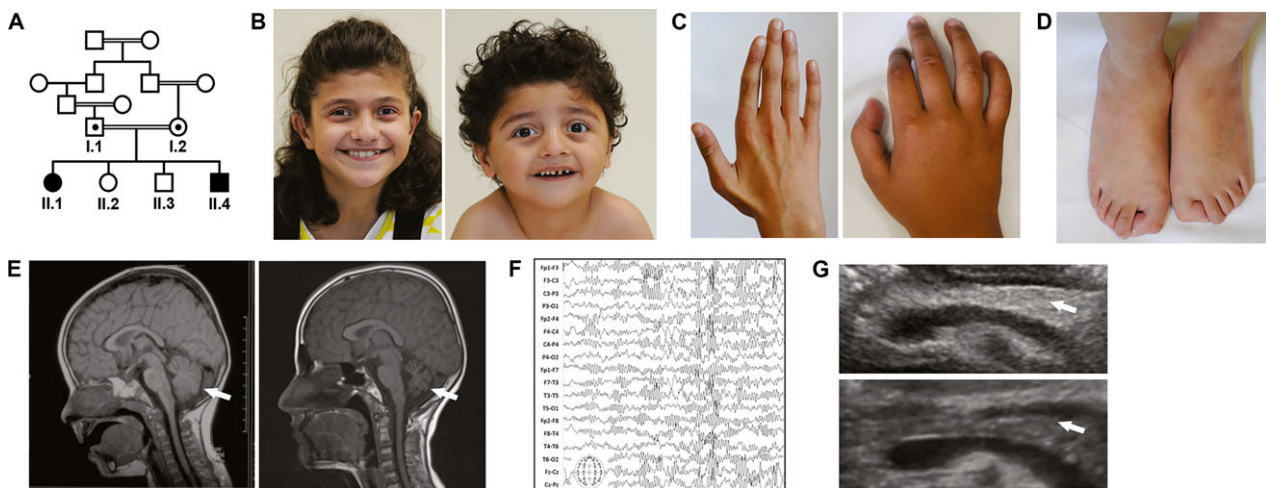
Phenotype of patients with infantile-onset multisystem neurologic, endocrine, and pancreatic disease (IMNEPD). (A) The index patients (II.1, II.4) are children of healthy, consanguineous Yazidian parents from Turkey. (B) Both patients displayed facial dysmorphism with midface hypoplasia, hypertelorism, exotropia, and thin upper lip (II.1: 13 years, II.4: 5 years) and deformities of (C) fingers and (D) toes (II.1). (E) Cranial MRI revealed progressive cerebellar atrophy (II.1: left at 2 and right at 12 years of age). (F) Abnormal rhythmic alpha-beta waves with high amplitudes on EEG recording (II.1). (G) High echo intensity of the pancreas (arrow) of the affected female patient II.1 (top) compared to that of a healthy, age-matched control (bottom) in an abdominal ultrasound indicates organ fibrosis and/or increase in fatty tissue.
